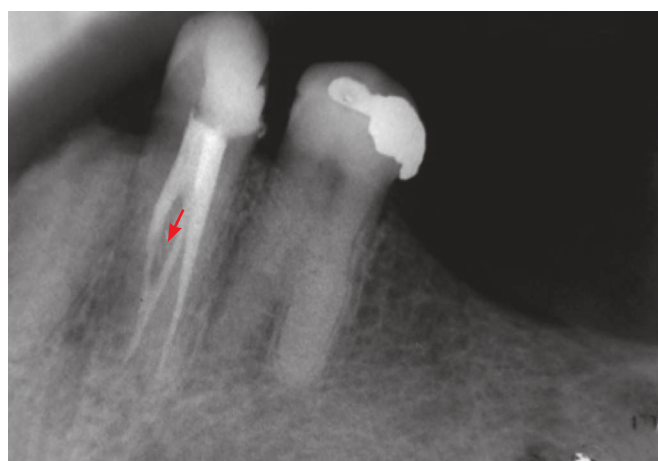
Final radiograph showing three canals, one lingual and two buccal ones, connected by an intercanal (arrow).
